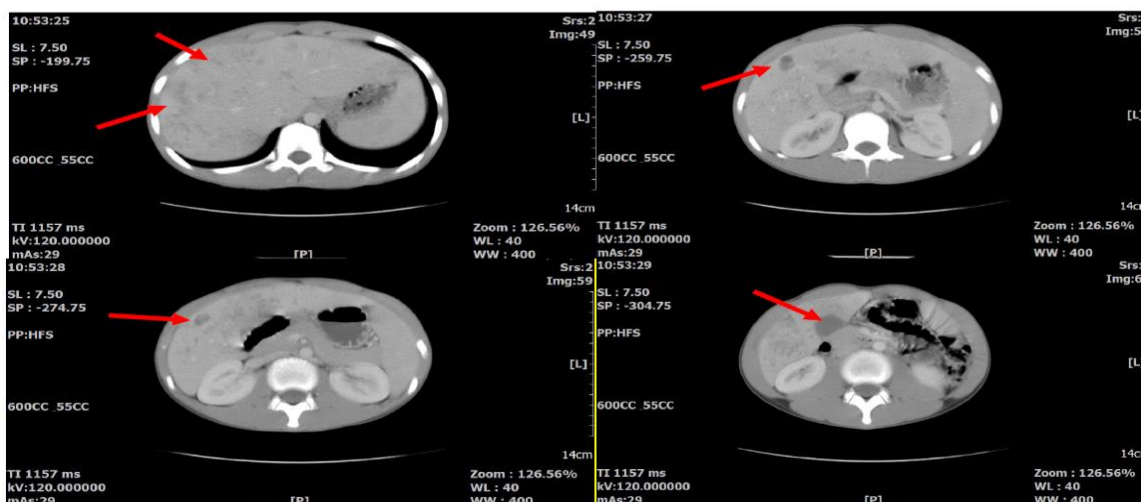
Abdomino-Pelvic CT scan (axial view) revealing multiple hypo-dense areas in the liver
